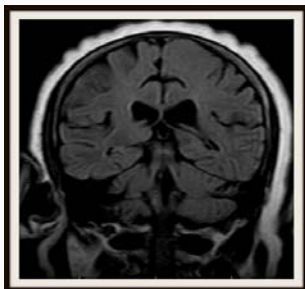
FLAIR imaging shows a clear hyperintensity in the right lateral medullar area, matching the clinical presentation.
